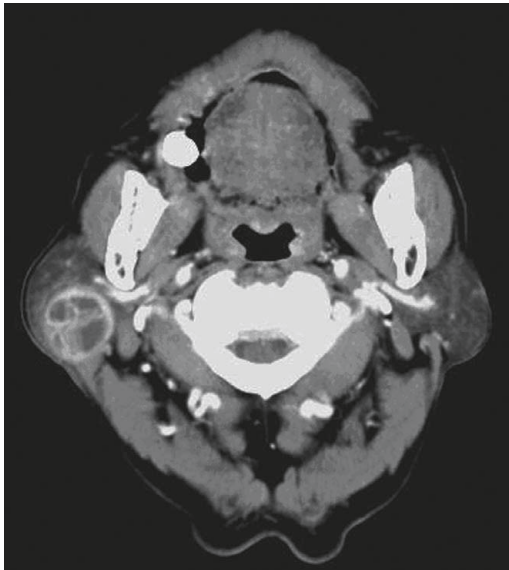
Computed tomography shows an ovoid well-enhanced mass with multiple central cystic changes over the right parotid gland.
